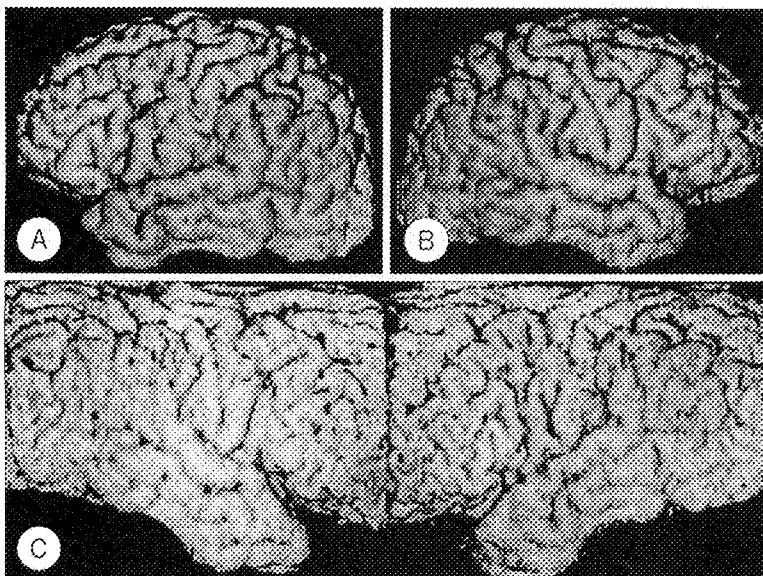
3D surface-projection rendering showing left and right hemispheres (A, B). Spherical 3D surface rendering of brain MRI were stretched out on 2D plane (C : radial surface rendering) and symmetry of sulco-gyral patterns in both hemispheres can be compared side by side.
